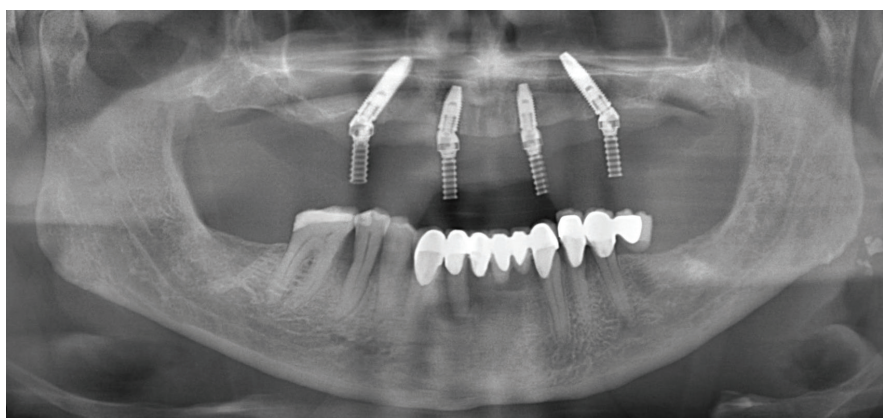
Representative post-operative orthopantomography of the same patient rehabilitated with a maxillary All-on-four.
